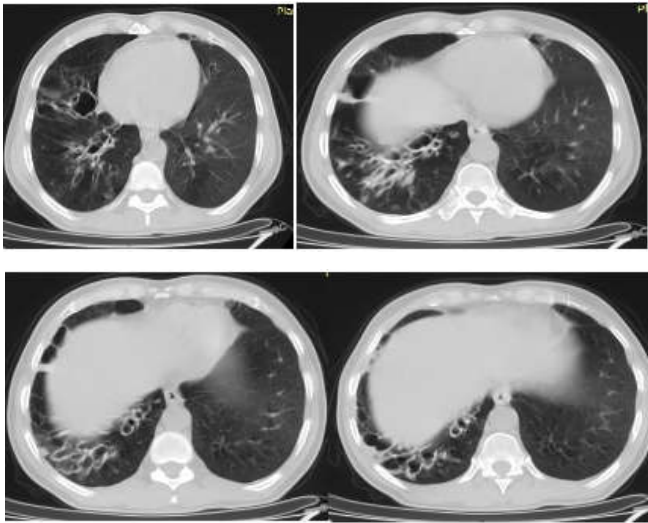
HRCT of 28 years male smoker with history of pulmonary tuberculosis shows characteristic right lower lobar cystic bronchiectasis
